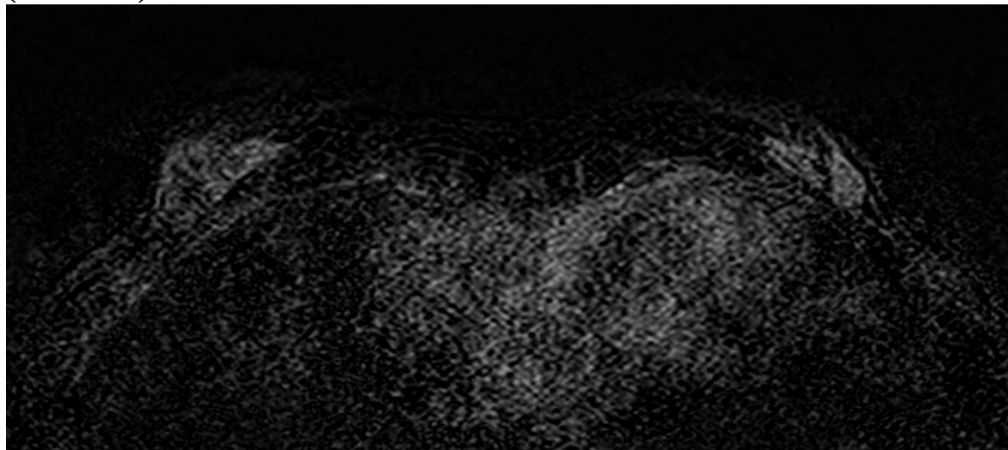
Axial MRI subtracted with standard sequence: lesion of left breast is not visible because of the BPE
